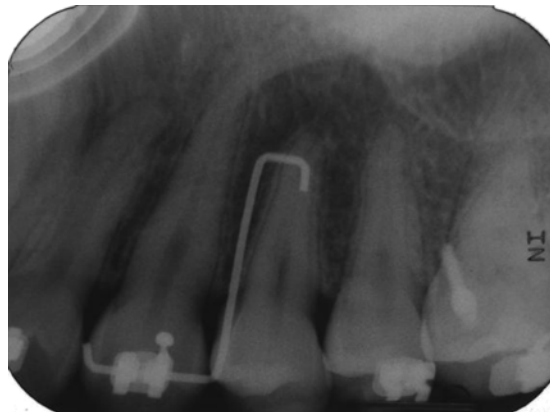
Surgical guide wire in periapical radiograph.
